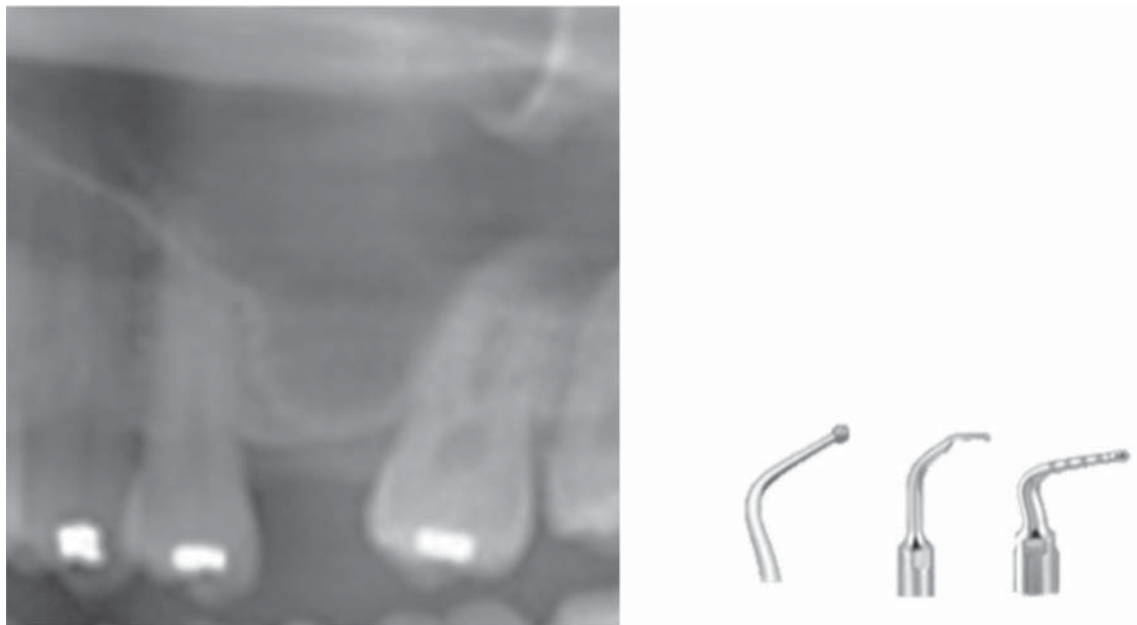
The tips of the “Piezoelectric Ultrasonic Surgery Unit” used in this case. From left to right: drill for osteotomy (SL-3 tip), sinus membrane separation that is also used in lateral window sinus lift (SL-7 tip), and sinus membrane elevation (SL-9 tip; with internal irrigation) that is used in the crestal approach.
